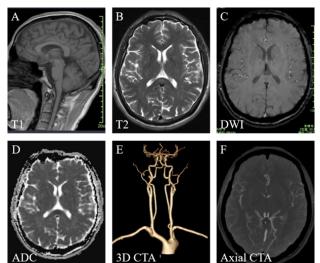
Brain MRI and CTA. (A) Axial longitudinal relaxation time-weighted imaging (T1WI) show isolated splenial ovoid lesion of low signal intensity; (B) transverse relaxation time-weighted imaging (T2WI) show higher signal intensity at the same location; (C) diffusion-weighted imaging (DWI) show splenial hyperintensity, and (D) apparent diffusion coefficient (ADC) show reduced diffusion restriction at splenium of the corpus callosum; (E) Three-dimensional reconstruction and (F) Axial CTA shows no obvious abnormalities.
